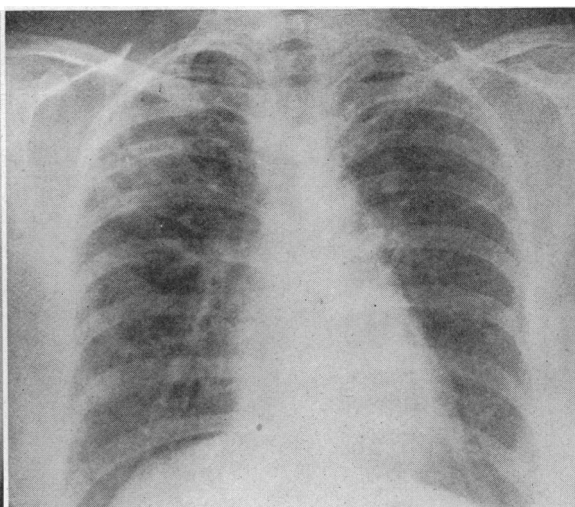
A predominantly proliferative lesion, involving chiefly the right upper but distributed throughout both lungs, in a woman of forty-five. Insidious onset with mildly febrile course for several months. For the past five years this woman has been leading a normal life, but the character and extent of the lesion, as far as x-ray evidence is concerned, have not changed since she was first seen, six years ago.
